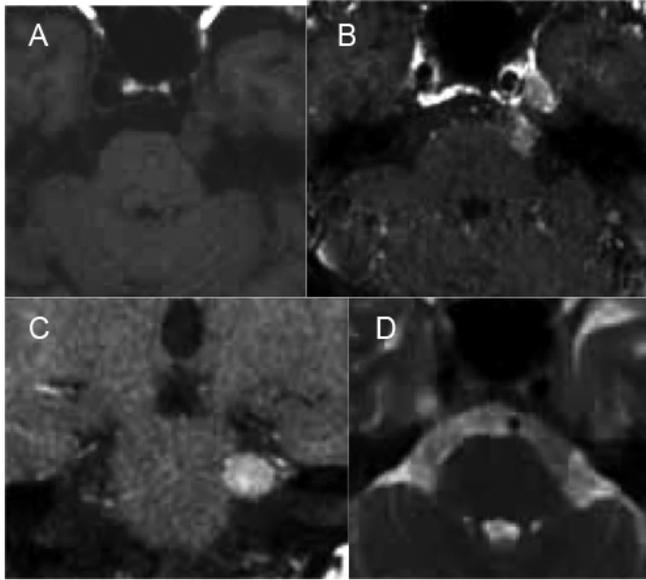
Preoperative T₁-weighted magnetic resonance (MR) imaging showing an isointense (A) and large heterogeneously enhanced large tumor in response to gadolinium on axial (B) and coronal imaging (C) along the left trigeminal nerve. T₂-weighted MR image (D) shows an isointense mass.
